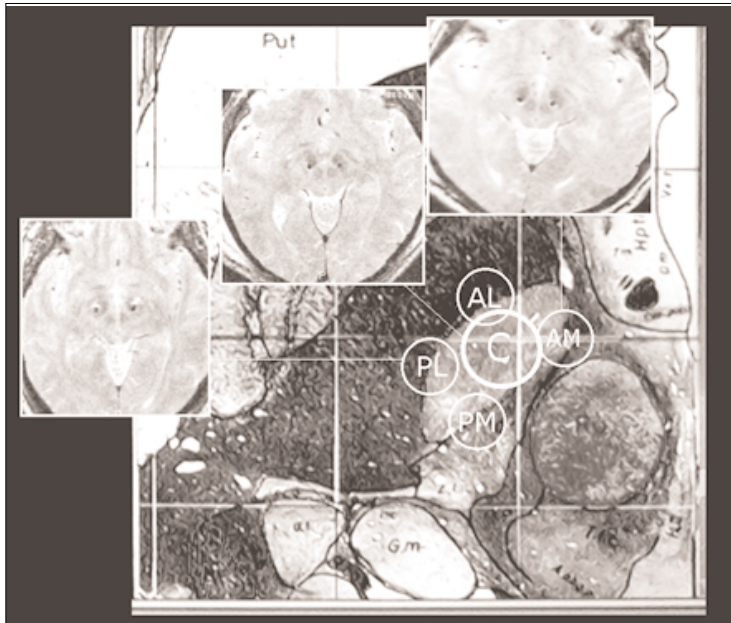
The position of the definitive electrocatheter as visualised on MRI is then reported onto the Schaltenbrandt Atlas axial view of the subthalamic area. Each circle corresponds to a discrete part of this area
